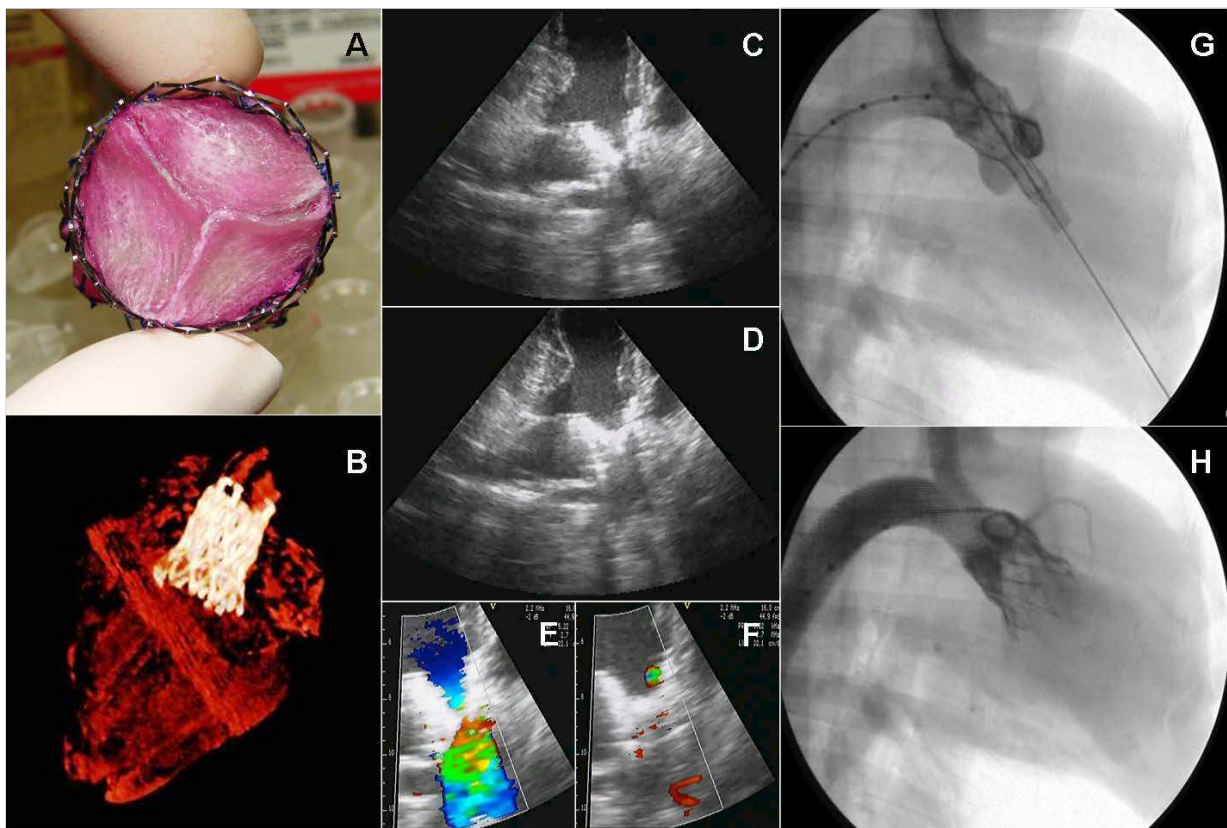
First orthotopic, transapical, tissue-engineered heart valve implantation into the aortic position: Based on the one-step procedure, marrow stromal cell based tissue engineered heart valves (A) were transapically implanted into the orthotopic, aortic position. Optimal positioning was confirmed using 3D computed tomography reconstruction imagery (B) and fluoroscopy (G). In the trans oesophageal echocardiography the implanted heart valves displayed excellent functionality with sufficient opening and closing (C-F) which was also confirmed in the fluoroscopy (H). In particular, there were no signs of coronary occlusion or perfusion compromise (Emmert et al, unpublished data).
